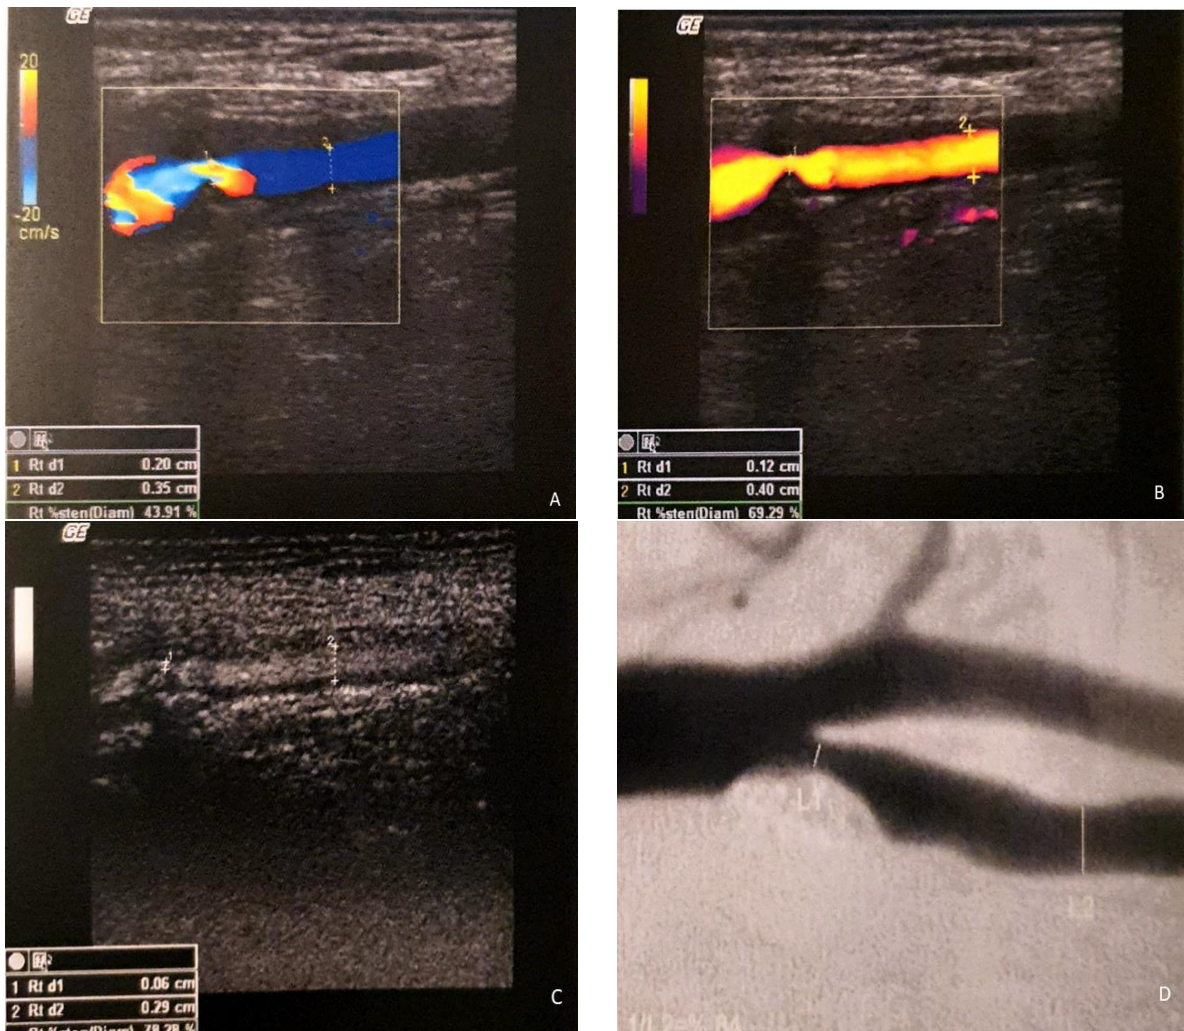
70-year-old male patient with stenosis in left internal carotid artery graded as 44 % in color Doppler (A), 69% in power Doppler (B), and 78% in B-flow (C). Here B-flow imaging correlated well with DSA (D) which graded the stenosis as 84%.
